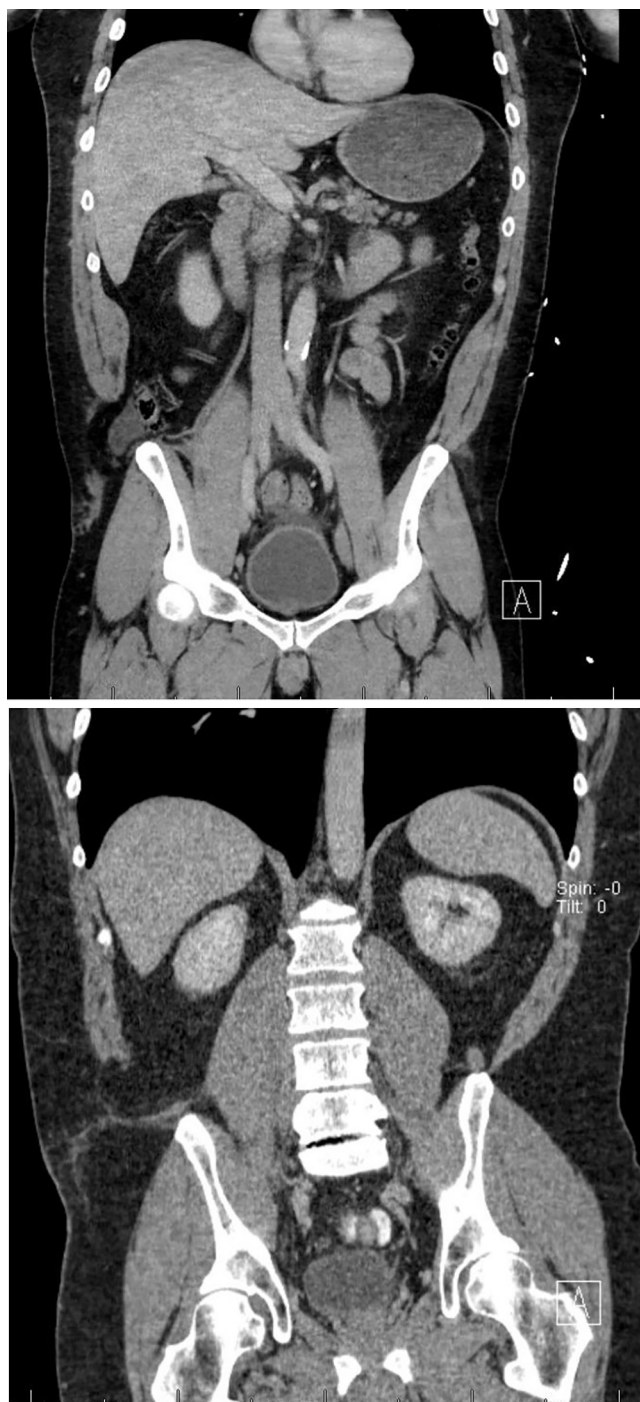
a) Computed Tomography of patient during initial evaluation showing defect of oblique musculature. b) CT of patient during pre-operative planning phase showing same defect.
